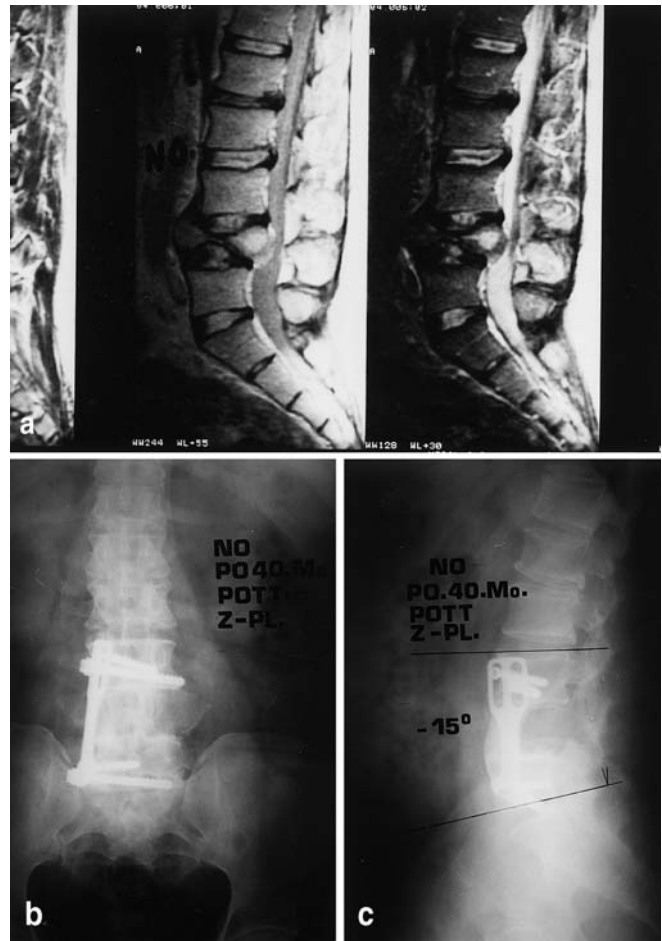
A 36-year-old man (N.O.) with Pott's disease in the L4 vertebra. Two mobile segments were instrumented with anterior Z-plate and a 100% correction rate was obtained after anterior radical debridement and strut grafting. There was a 5° loss of correction and solid fusion mass was observed at the last visit. A Preoperative magnetic resonance (MR) image, sagittal view, and B posteroanterior and C lateral radiographs, 40 months after surgery
